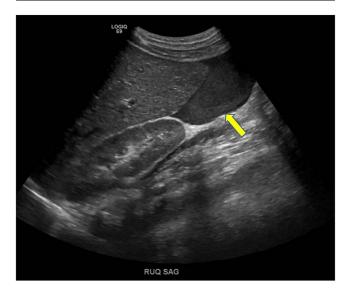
Right upper quadrant sagittal ultrasound demonstrating hemoperitoneum along the inferior hepatic margin.
